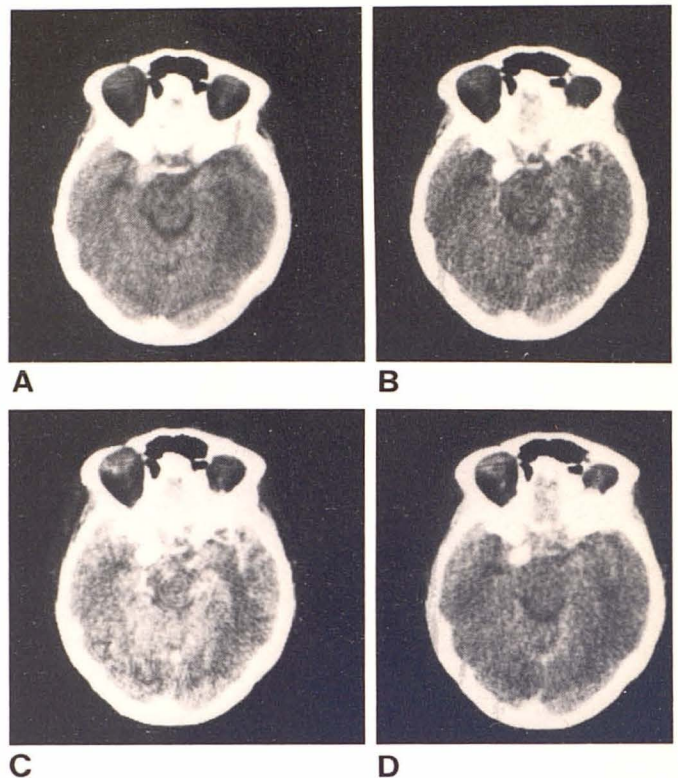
Posterior communicating artery aneurysm shown by dynamic CT. Note early, dense contrast material accumulation in the aneurysm. A, Pre-contrast. B, 9–12 sec. C, 17–20 sec. D, 4 min 45 sec.
